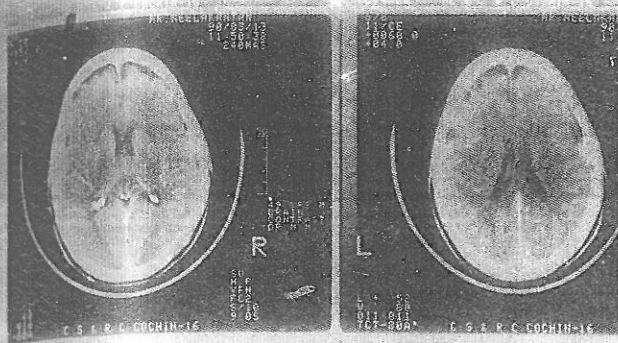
CT scanning of the brain. Note less prominence of the cortical sulci, particularly in the frontal region.
